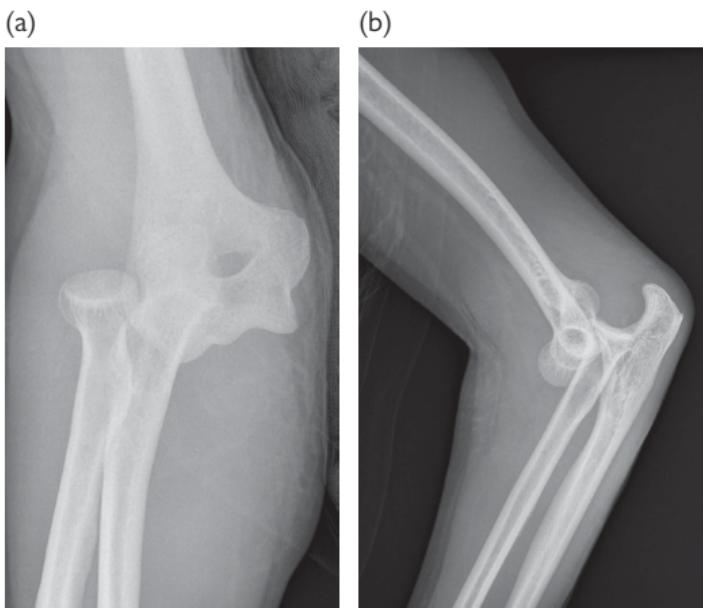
X-rays of postero-lateral elbow dislocation.
